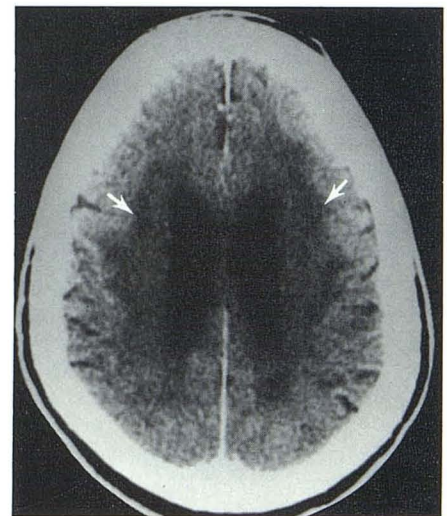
Diffuse involvement of white matter secondary to autopsy-proven CMV encephalitis manifested on CT by marked hypodensity in periventricular regions (arrows) and centrum semiovale.
